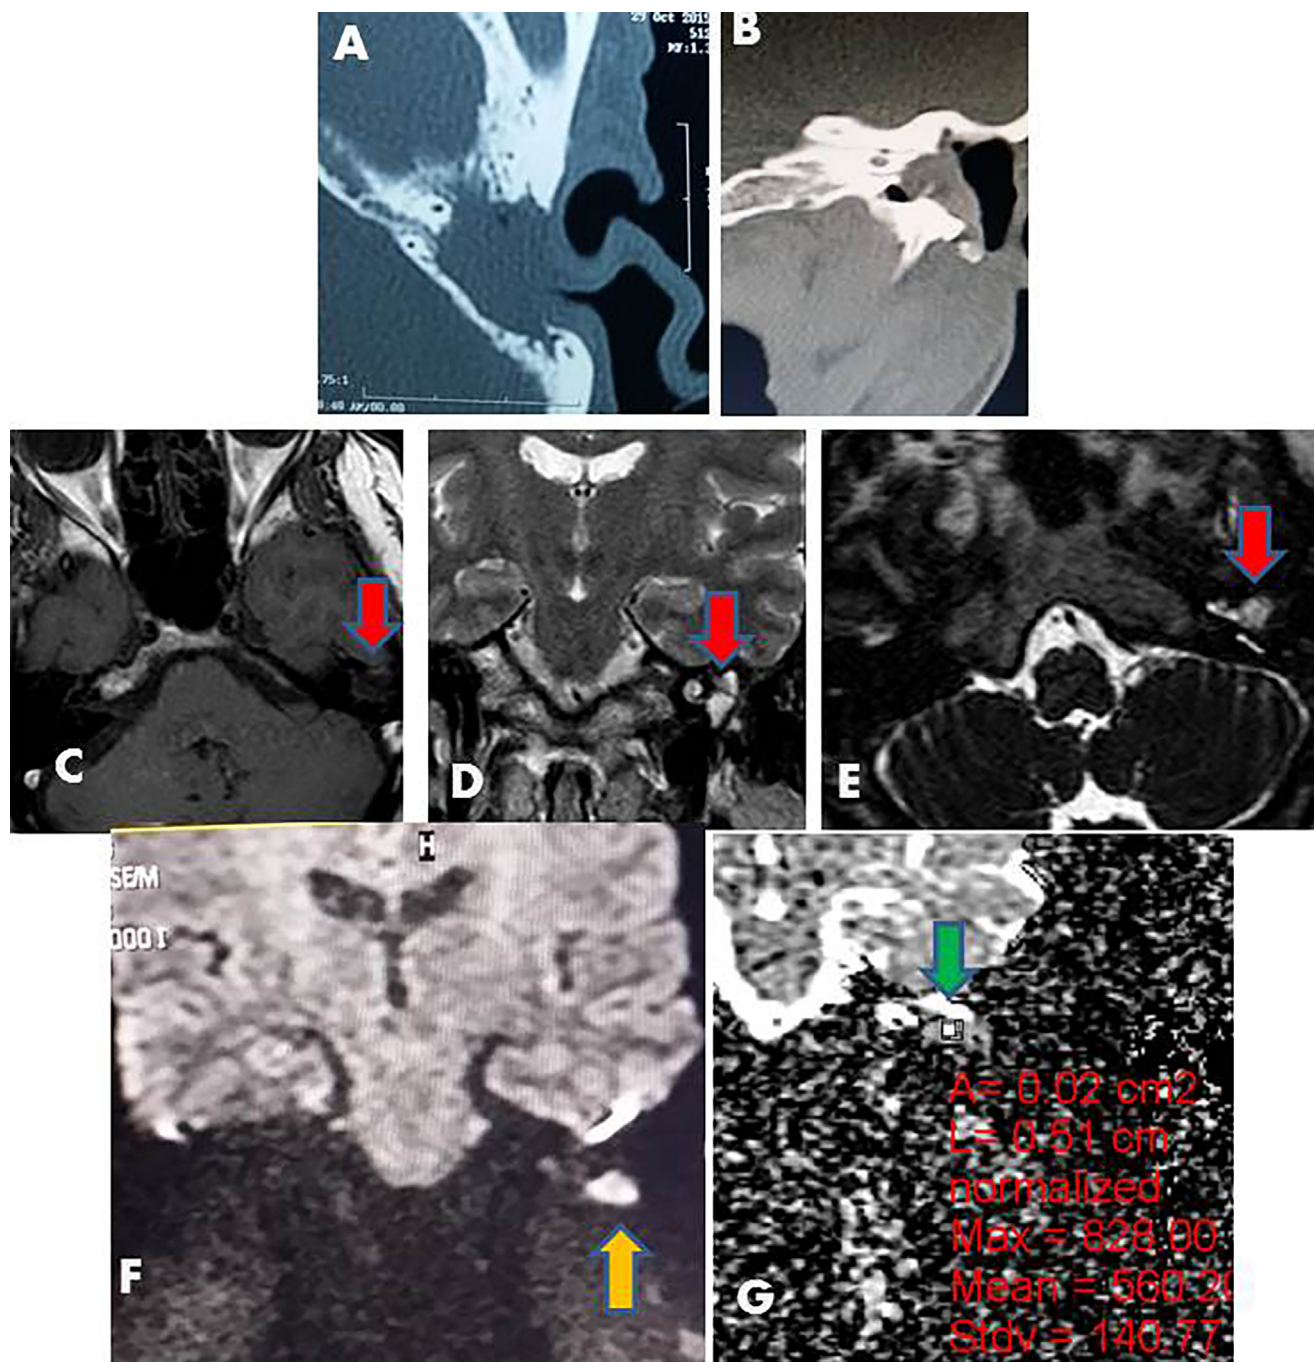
Recurrent cholesteatoma in the left middle ear of a 50y old woman who underwent CWD ear surgery. (A and B) Axial and coronal CT cuts revealed complete opacification of the right middle ear cleft, absent ossicles. (C) Axial T1WI, (D) Axial CISS and (E) Coronal T2W MRI sequences showed a soft tissue lesion in the right middle ear cleft of hypointense signal at T1WI and high signal intensity at T2WI and CISS (Red arrow). (F) Coronal DWI fast SE image obtained with a b factor of 1000 s/mm² showed markedly high signal intensity of the cholesteatoma (yellow arrow). (G) ADC (mean 566×10^{-3} mm²/s), (green arrow). The lesion size is 2 cm at CT and 1 cm at DWI.
